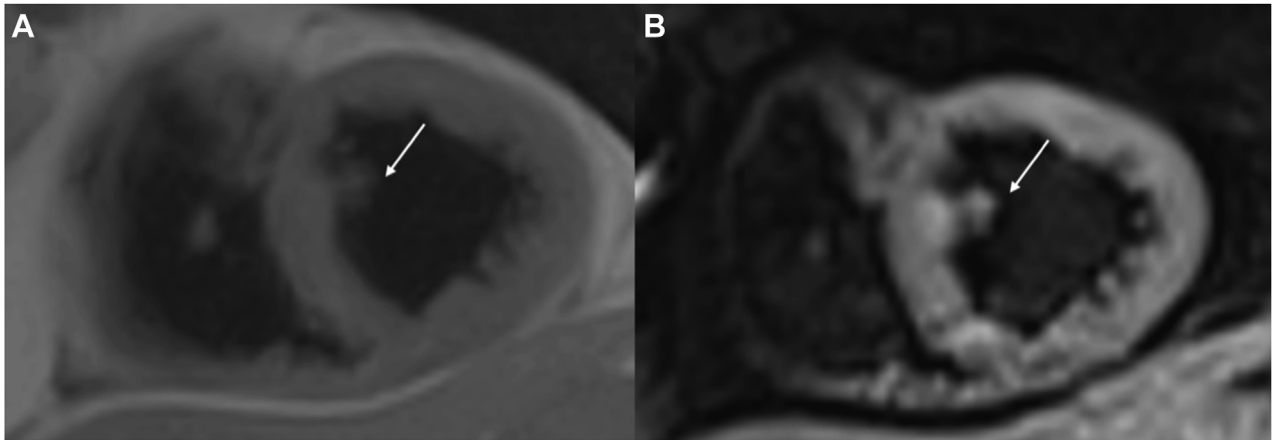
Short-axis CMR images with T2-weighted short Tau inversion recovery images without (A) and with (B) fat saturation showing the cardiac mass (*arrow*) attached to the septum and infiltrating the septum, which is isointense with the myocardium and does not suppress with fat saturation.
